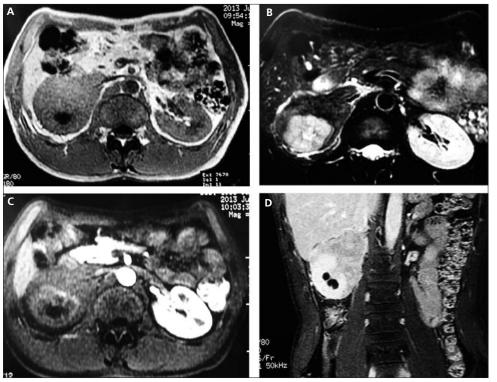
MRI shows the perirenal mass (right) with low intense signal in T1W/T2W images (A, B), mainly situated in the hilum and upper pole of right kidney (D). The mass involved part of the wall of vena cava without intruded into its luminal (A, B), The right kidney with hydronephrosis was enhanced poorly compared with the left one (A, C).
